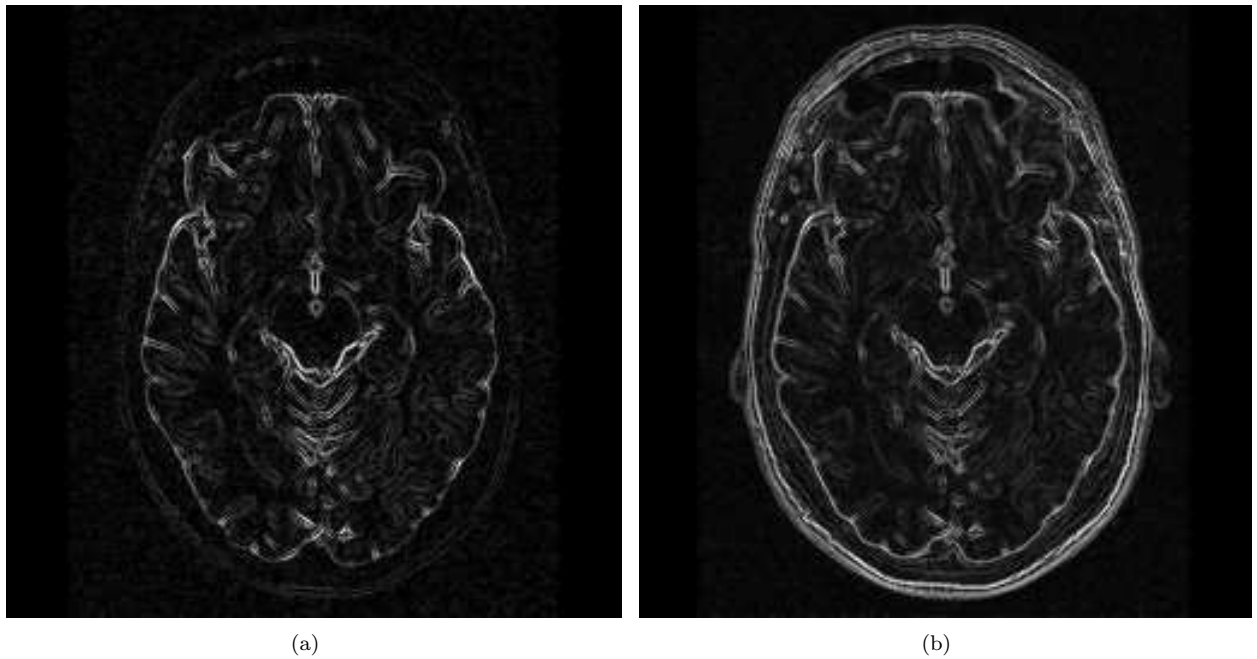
Gradient of single (a) and multiple (b) MR images of the brain.
